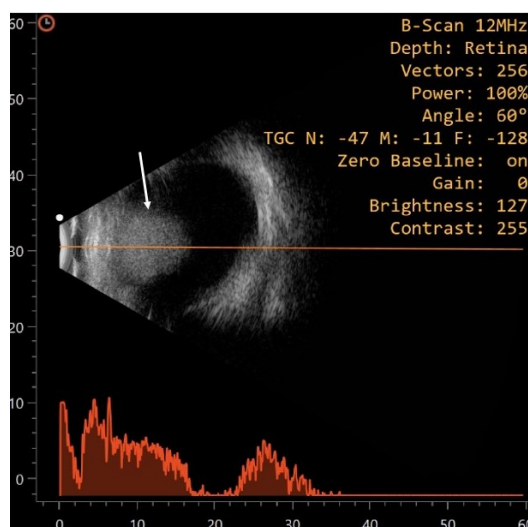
Ultrasonography showing a retro-pupillary mass lesion occupying the ciliary body area.
